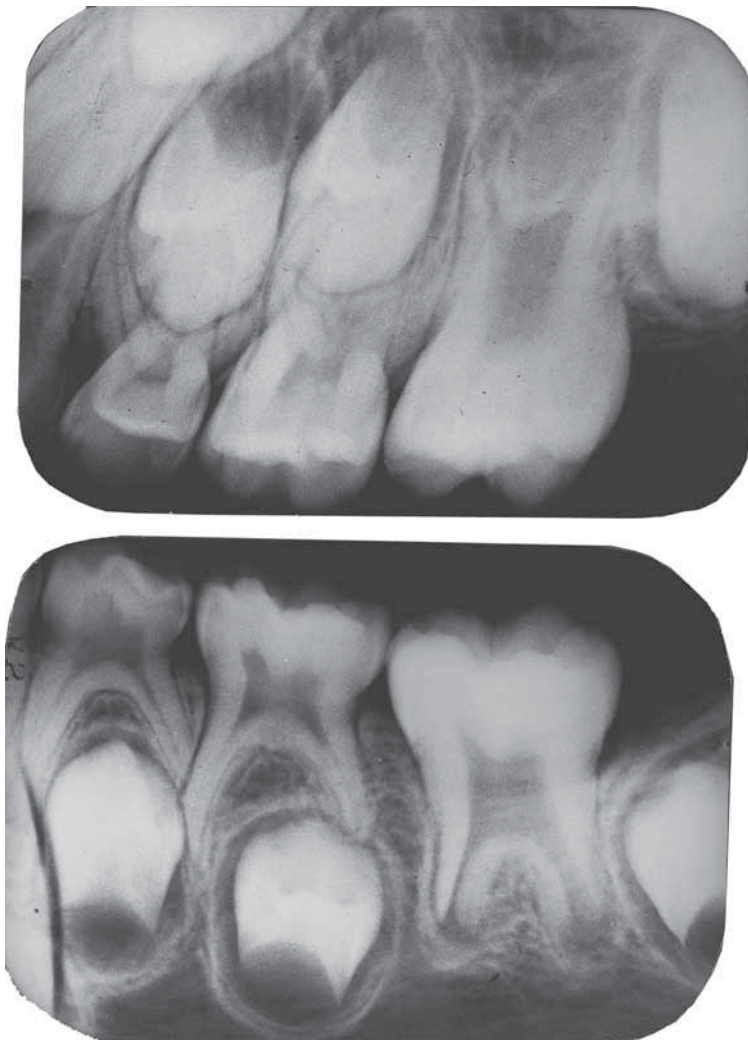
Radiographs made of an 8-year-old child showing the first and second primary molars and first adult molars in the mouth. The top radiograph shows maxillary teeth, and the lower radiograph shows mandibular teeth. Notice the premolar crowns between the partially resorbed roots of the maxillary and mandibular primary molars. Part of the 12-year second molar crown is seen on the far right of each radiograph. The smaller size, thinner enamel, and relatively larger pulp cavities are evident in the primary molars compared to the larger secondary molars just distal to them. (Courtesy of Professor Donald Bowers, The Ohio State University.)
